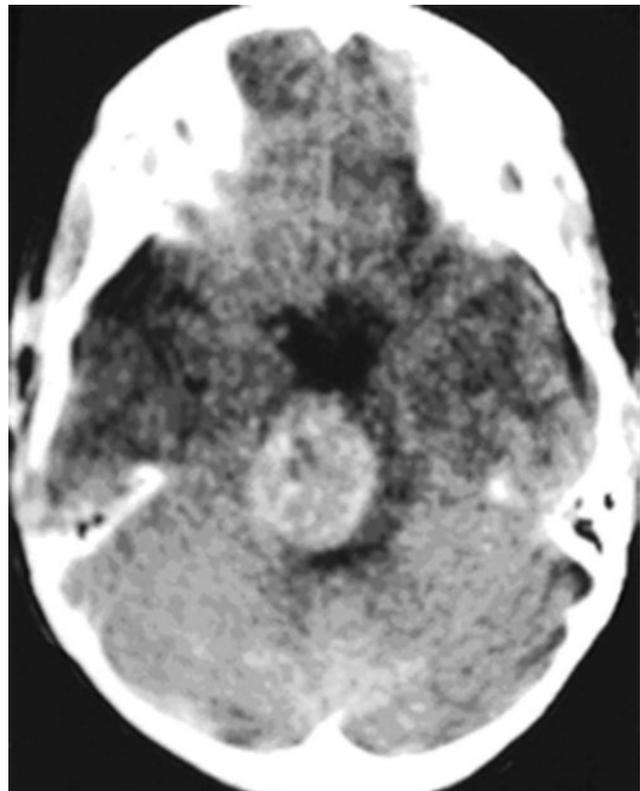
Computed tomographic scan, unenhanced, demonstrating a massive cavernous malformation of the lateral pons and brainstem. The study shows extensive intralésional high-signal attenuation reflecting probable calcium deposition within the lesion.
